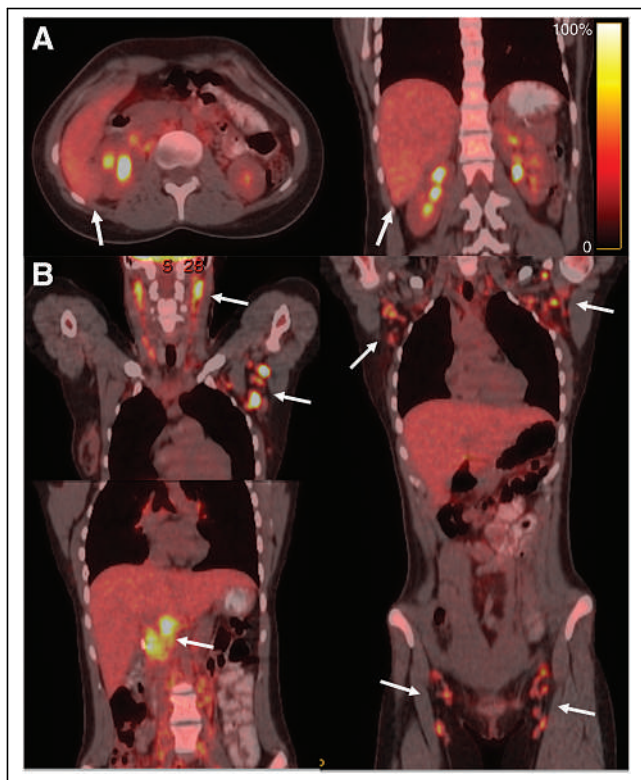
^{18}F -FDG PET/CT images of lesion and lymphadenopathy (arrows). (A) Axial (left) and coronal (right) images show liver lesion exhibiting glucose metabolic activity similar to that of surrounding normal parenchyma. (B) Coronal (bottom left and right) images show widespread ^{18}F -FDG-avid lymphadenopathy.
